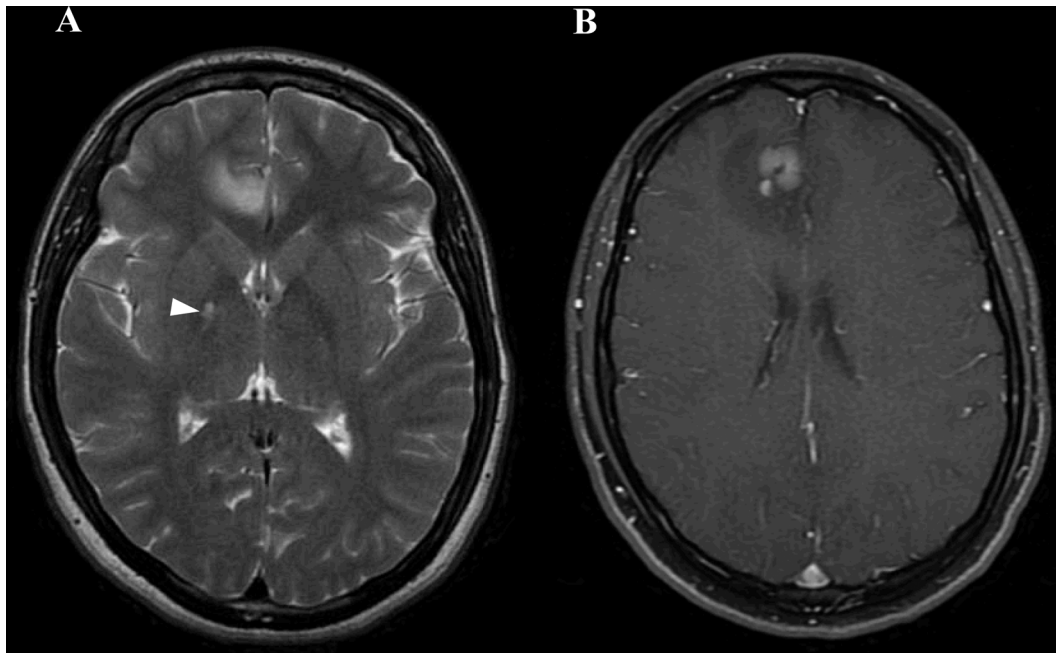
MRI findings at primary central nervous system lymphoma recurrence demonstrates a T2 hyperintense frontal recurrence (A) with postgadolinium enhancement (B) and improvement of the T2 haemorrhagic changes (arrowhead).
